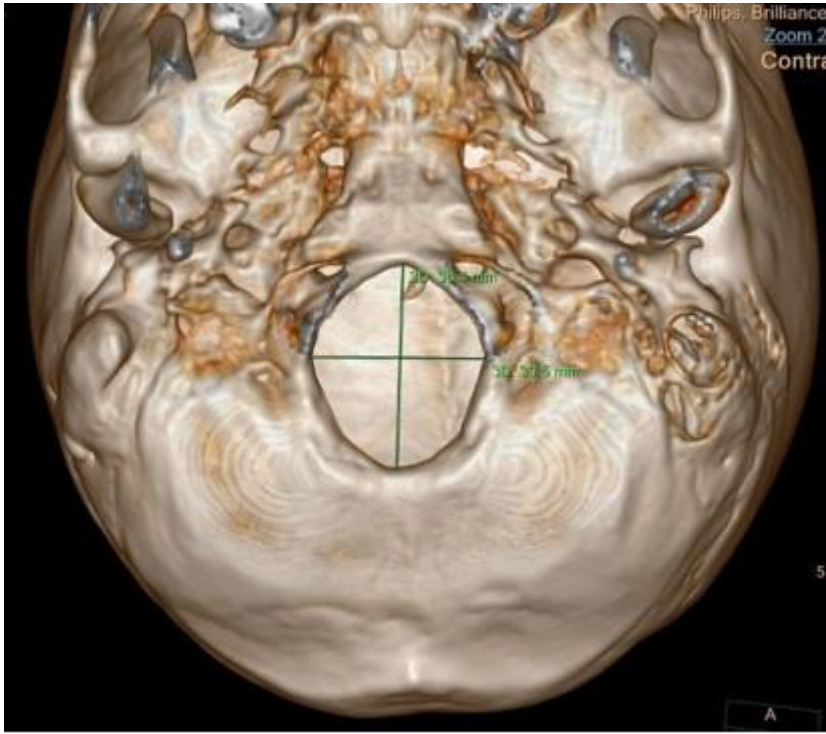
Measurement of foramen magnum dimensions on a three-dimensional volume rendering CT image of the skull base
